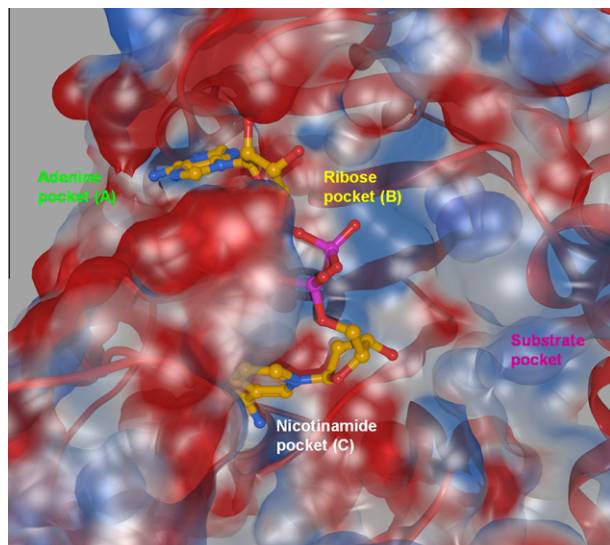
X-ray structure of human Sirt2 in complex with NAD⁺ (predicted by docking). The molecular surface of the protein is colored according to the electrostatic potential (red = negative potential, blue = positive potential).
